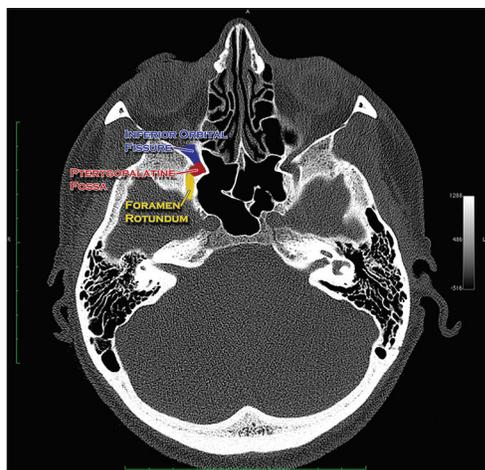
CT scan (bone window) axial section through the uppermost portion of the pterygopalatine fossa
